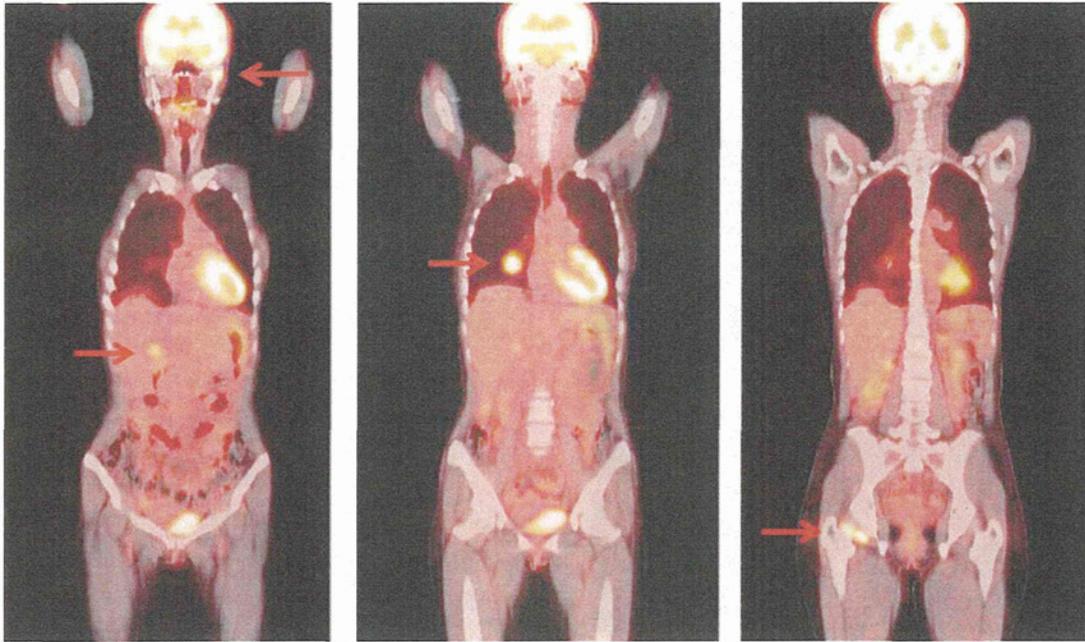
(Right) Whole body fluorine-18-deoxyglucose PET-CT revealed a density anomaly mass in the liver and left mandibular condyle with increased glucose metabolism. (Center) Increased glucose metabolism in the lower left lobe, (left) increased glucose metabolism in the right common iliac artery lymph node.
